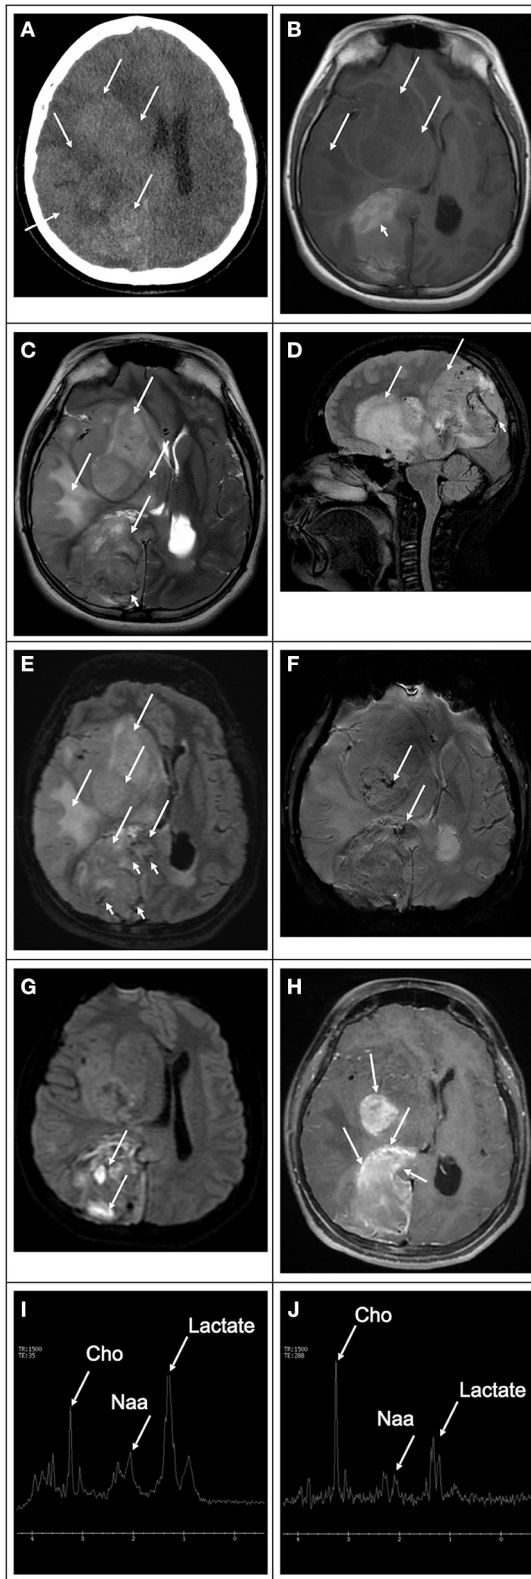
8-year-old- female with a hemispheric glioblastoma. (A) Computed tomography image in the axial plane shows an extensive mass in (Continued)
